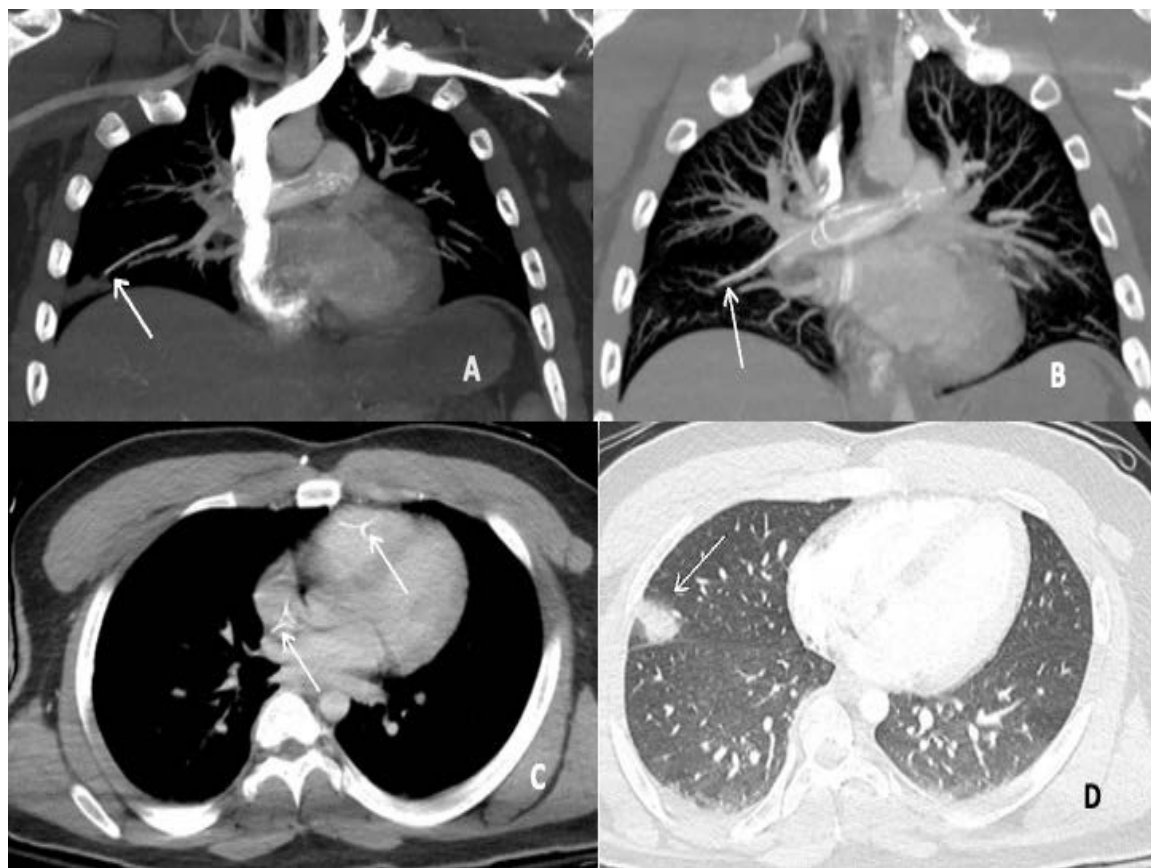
Initial outside hospital chest CTA demonstrating a foreign body within the right atrium, right ventricle, and pulmonary trunk, with associated thrombus resulting in complete pulmonary artery occlusion and pulmonary infarction. Coronal images windowed to the soft tissues demonstrate a fine curvilinear hyperdensity in the pulmonary trunk (A&B) extending to a segmental right middle lobe pulmonary artery with a distal pulmonary infarction. Axial image windowed to the soft tissues demonstrate a fine curvilinear hyperdensity in the right atrium and ventricle (C). Axial images windowed to the lungs demonstrate a right middle lobe pulmonary infarction distal to the occluded pulmonary artery (D).
